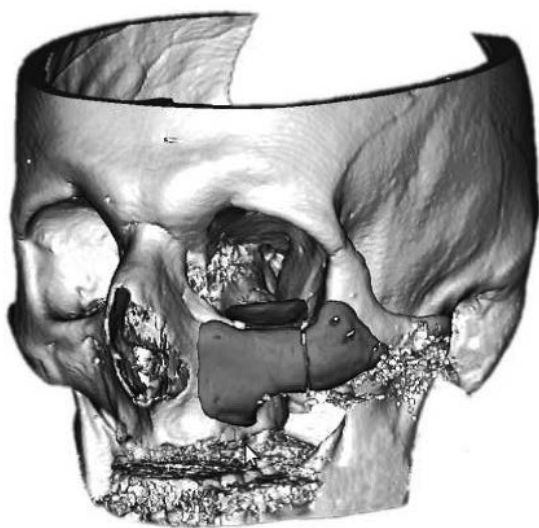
3D CT reconstruction with bone graft modelling (software).
